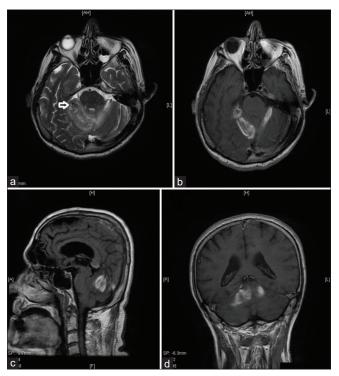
(a-d) Preoperative magnetic resonance images (a) axial unenhanced T2 weighted magnetic resonance imaging showing right-sided lesion (white arrow) and hyperdense areas which extends to the left cerebellum (hemorrhage) and there is no edema round the lesion. (b) Axial postcontrast T1 image, showing bilateral vermian lesions in which the right-sided mass is enhancing gadolinium peripherally. (c) Postcontrast sagittal image, demonstrating partly attachment of the mass to the tentorium. (d) Postcontrast coronal image demonstrates bilateral lesions close to the tentorium in mixt intensity
